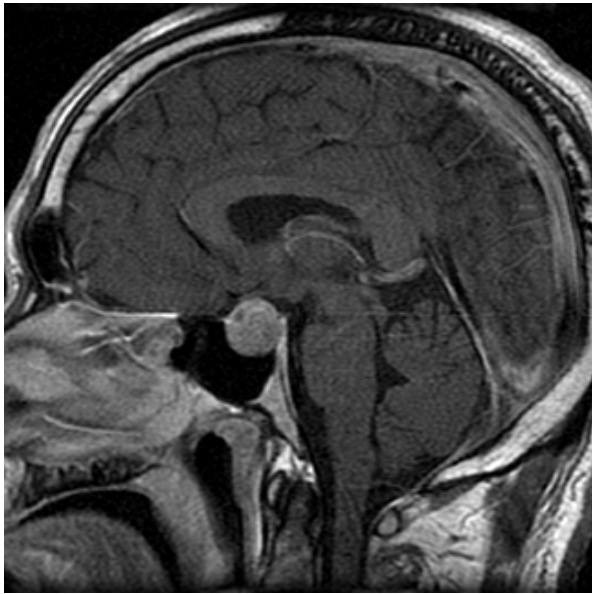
Magnetic resonance image (MRI) of a patient. Sagittal MRI showed that there was about $1.6 \times 1.2 \times 1.3$ cm sized hypoenhancing intra and suprasella mass. The mass was abutting to optic chiasm with mild compression.
